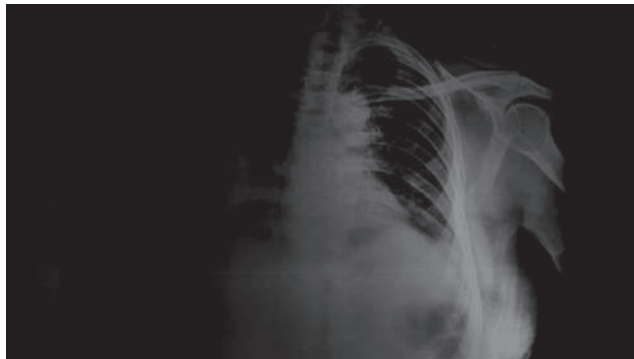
X-ray after 2 weeks of ATT showing resolution.
